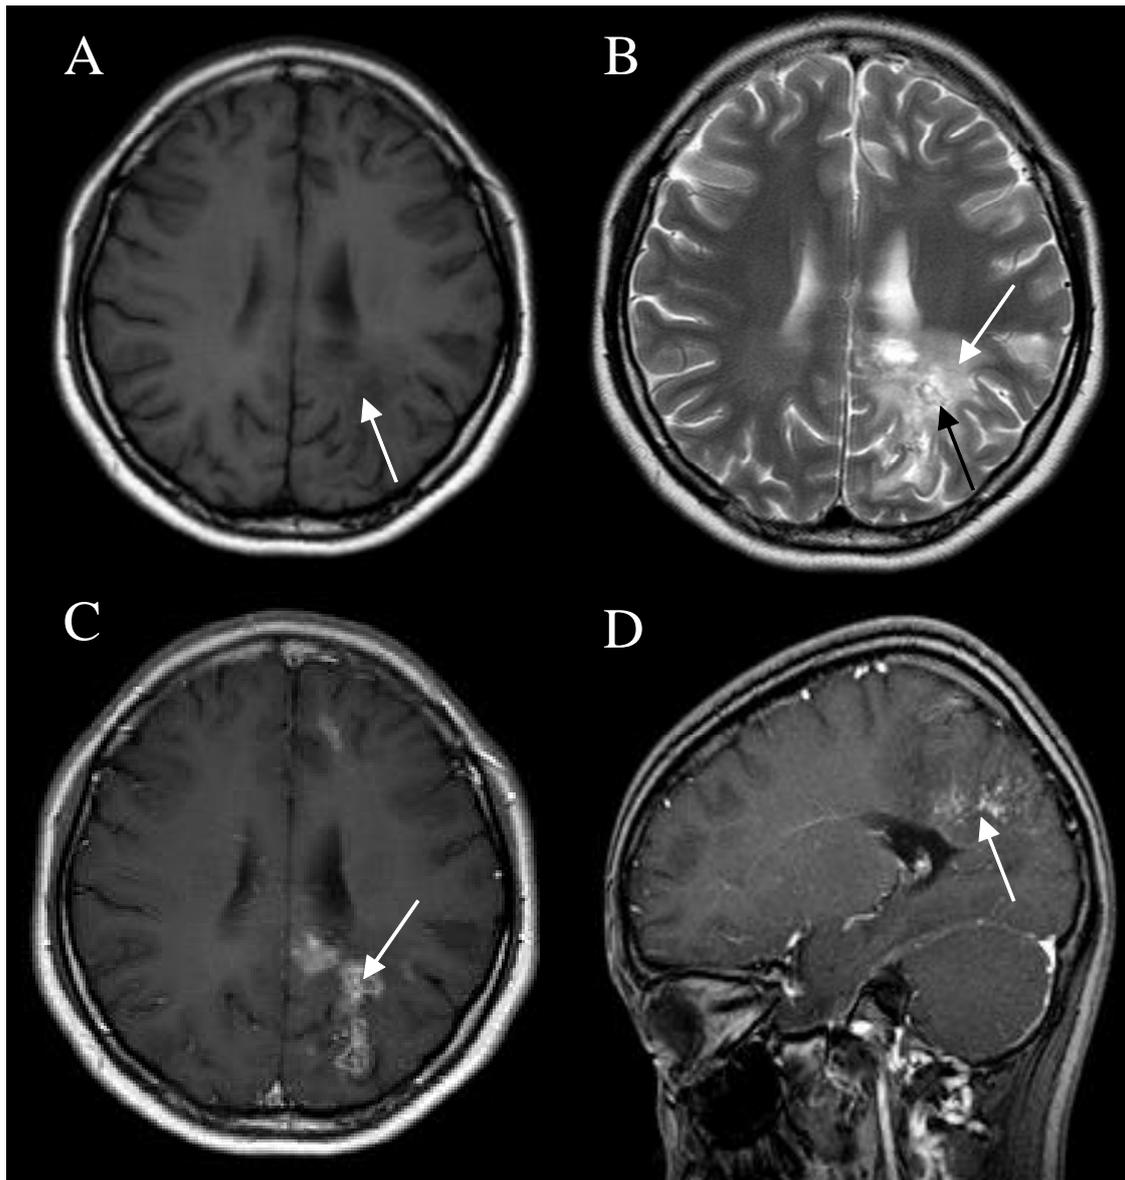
A cranial MRI taken during patient admission. (A) Irregular flake low signal focus in the white matter of left parietal lobe and its edge was vague (T1-weighted imaging, T1WI). (B) Focus presented high signals and the surrounding boundary was not clear (T2-weighted imaging, T2WI). (C) Enhanced scan showed irregular enhancement focus and the range of enhancement was smaller than that of abnormal high signals observed in T2WI. (D) Tortuous beaded shape enhancement in left corpus callosum and parietal lobe in sagittal plane (diffusion weighted imaging, DWI).
